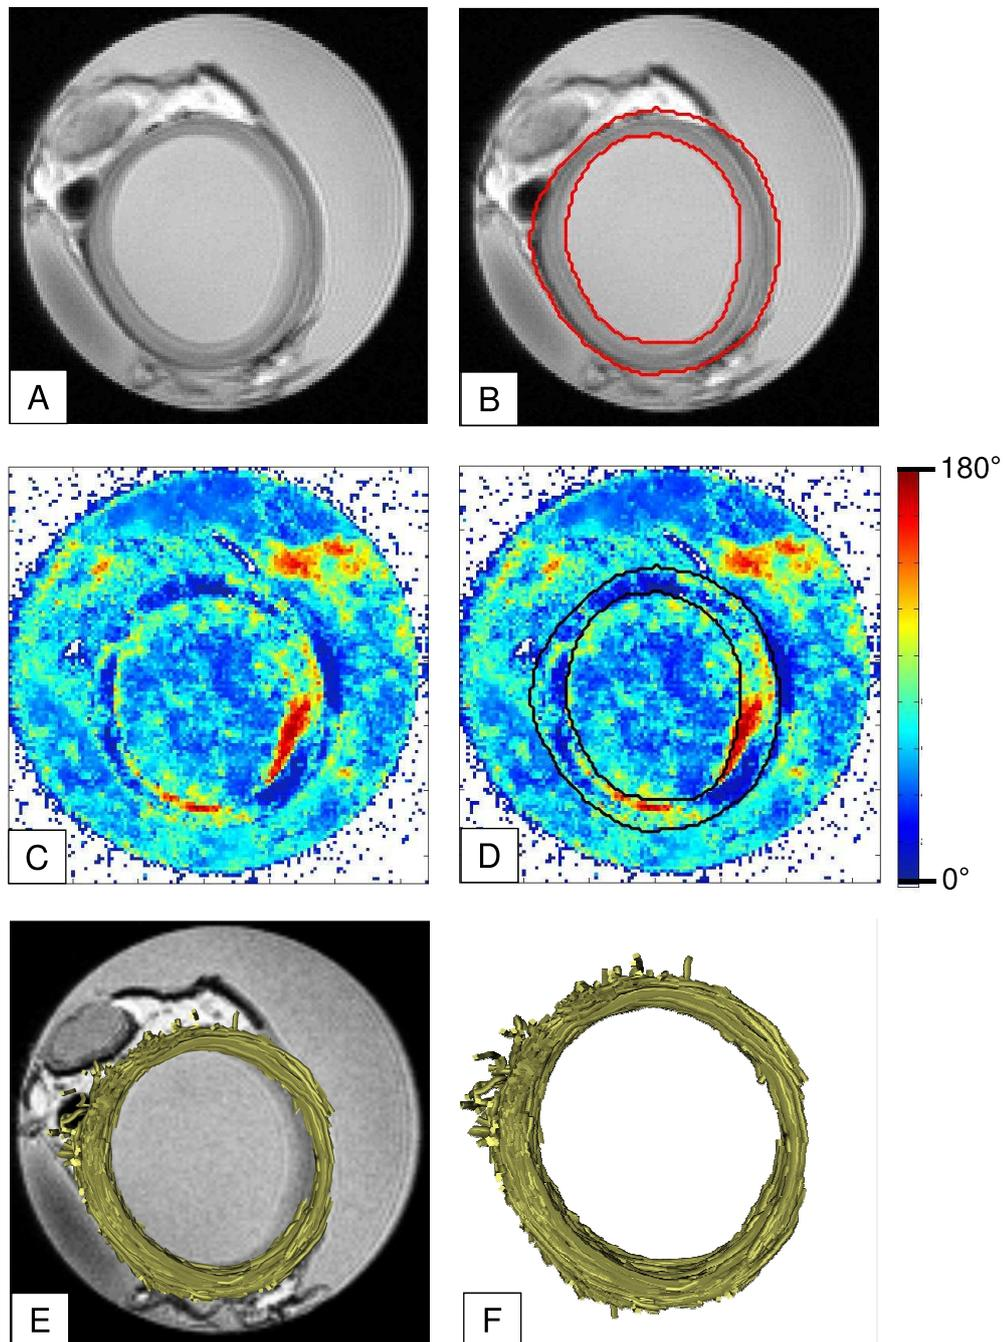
Steps in the DTI procedure and image postprocessing; (A) MRI anatomical scan, (B) The ROI of the aorta, (C) A map of the angle of the first eigenvector with the (x,y) plane, (D) A map of the angle of the first eigenvector with the (x,y) plane with the ROI clearly identified, (E) The results of the tractography process with the fibres superimposed on the reference image, and (F) The aortic fibres within the ROI alone.
